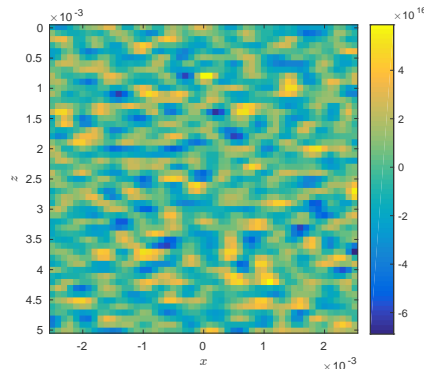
Single frame of ultrafast ultrasound (real part).
